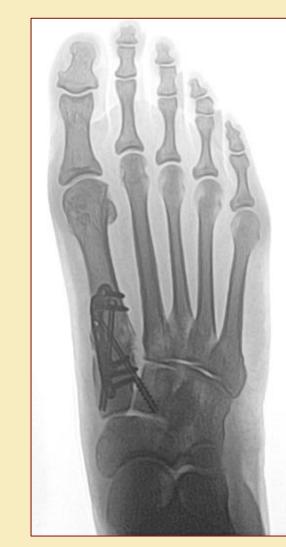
Pre and Post-op radiographs of Lapidus bunionectomy without intercuneiform fixation Figure 2) Pre and Post-op radiographs of Lapidus bunionectomy with intercuneiform fixation
